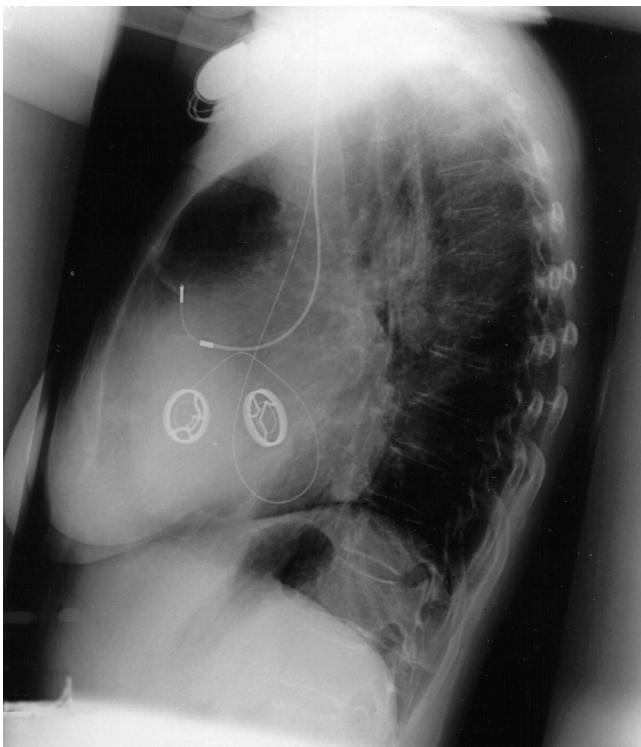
X-ray from the left oblique view, ventricular electrode follows the coronary sinus.
